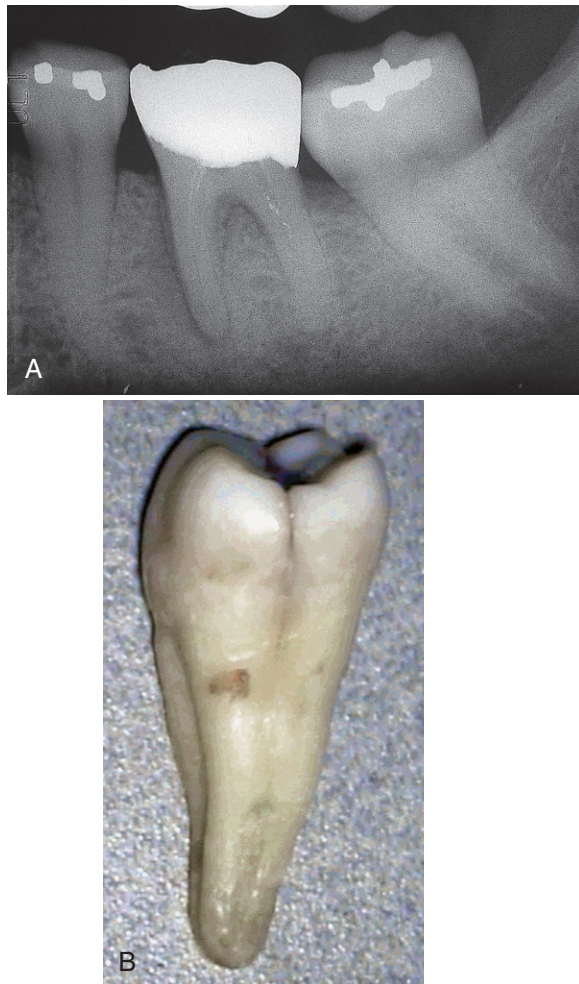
A, Radiograph showing loss of lamina dura on the mesial root of the mandibular molar but no indication of root fracture. B, Longitudinal fracture on the distal aspect of the crown and coronal root.
